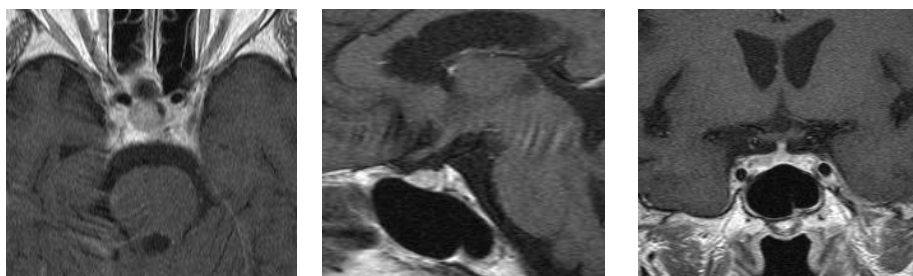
Post-operation MRI
